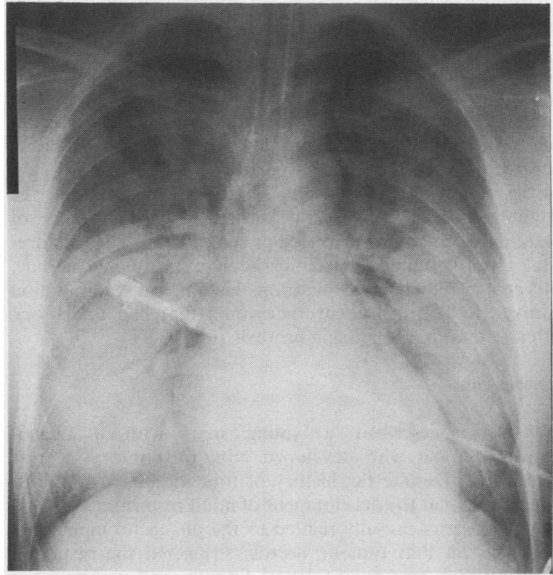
Chest radiograph on the second day of hospital admission, showing diffuse homogeneous shadowing throughout both lung fields.
